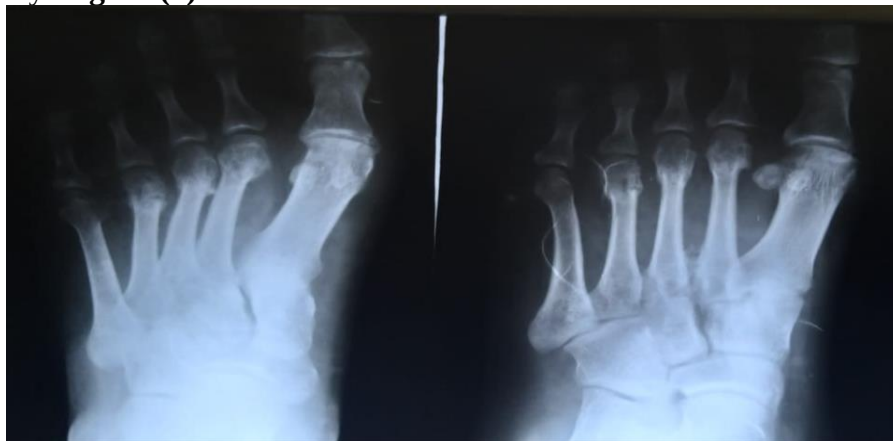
Radiographic consolidation of the metatarsal displaced head fractures after 8 weeks, showing a correct alignment, no angular deviations, and no shortening of the metatarsal bones.
